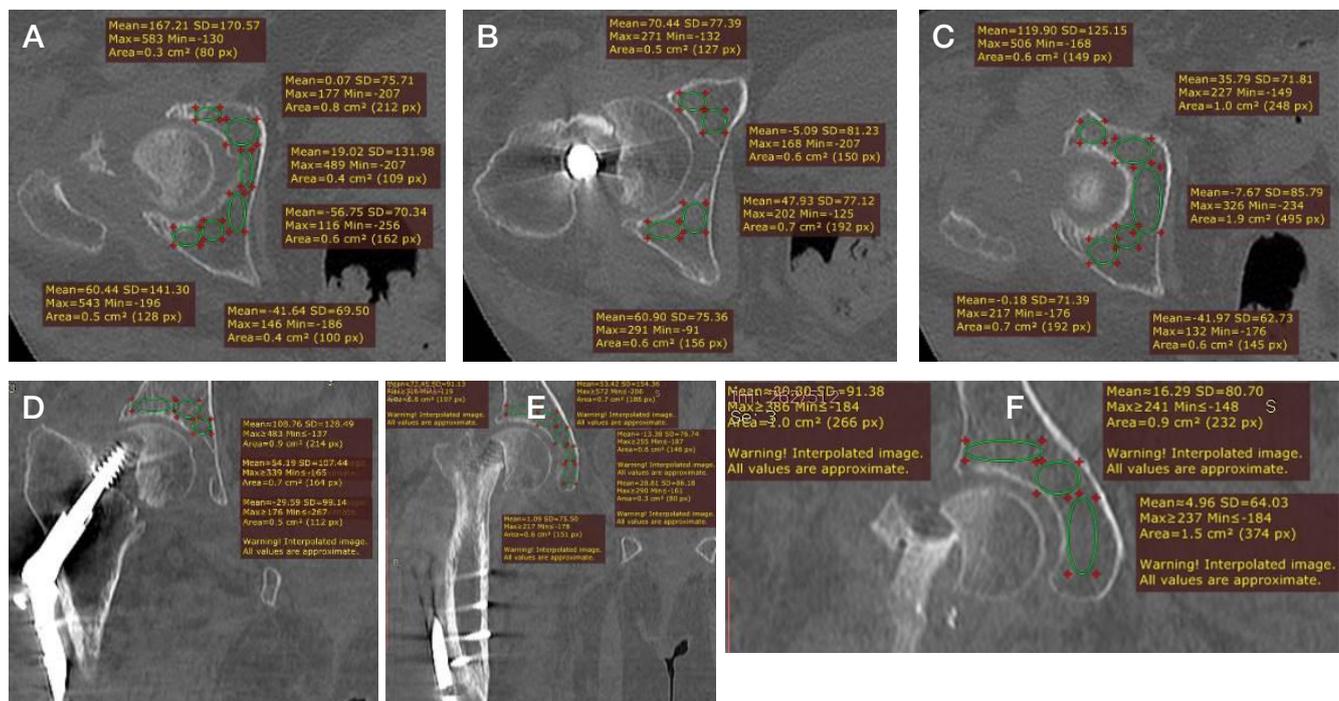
Determination of bone density in the zones of fixation located in the acetabular area based on the horizontal (A, B, C) and frontal (D, E, F) CT scans of the 73-year-old patient: at the level of inferior acetabulum (A); at the level of the acetabulum middle part (B); at the level of superior acetabulum (C) (Average total bone density according to the Hounsfield scale — 30.65 HU); at the level of posterior acetabulum (D); at the level of the acetabulum middle part (E); at the level of anterior acetabulum (F). (Average total bone density according to the Hounsfield scale — 30.09 HU.)
